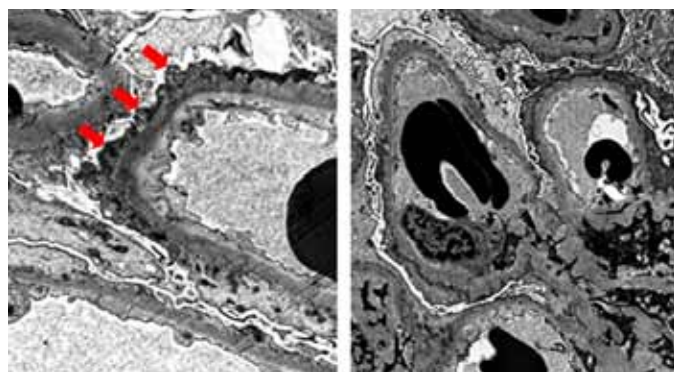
Two separate EM images of sample from patient's left kidney obtained via ultrasound-guided percutaneous needle biopsy, each showing notable podocyte effacement (demonstrated by red arrows) consistent with minimal change disease (Source: Health Network Laboratories).
